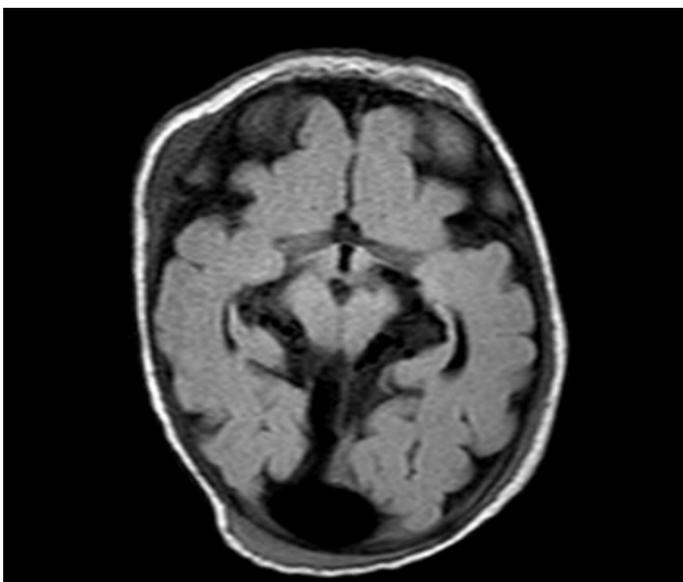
VGAM in brain MRI Brain
